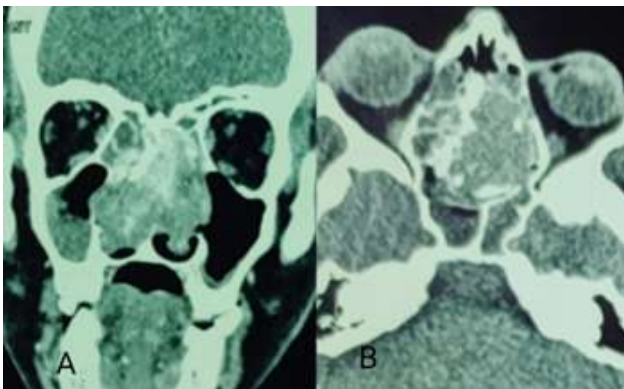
Computed Tomography of the Nose and Paranasal Sinuses in Axial (A) and Coronal (B) Sections, Showing Mixed Density Mass Arising From the Ethmoid Sinuses, Involving the Both Nasal Cavities.
